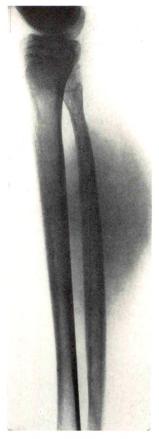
D. R., 15 year old male with progressive muscular dystrophy. Lateral roentgenogram of the right lower extremity shows marked widening, sclerosis and cortical thickening of the fibula. Again the marrow cavity appears narrowed in its upper portion.
